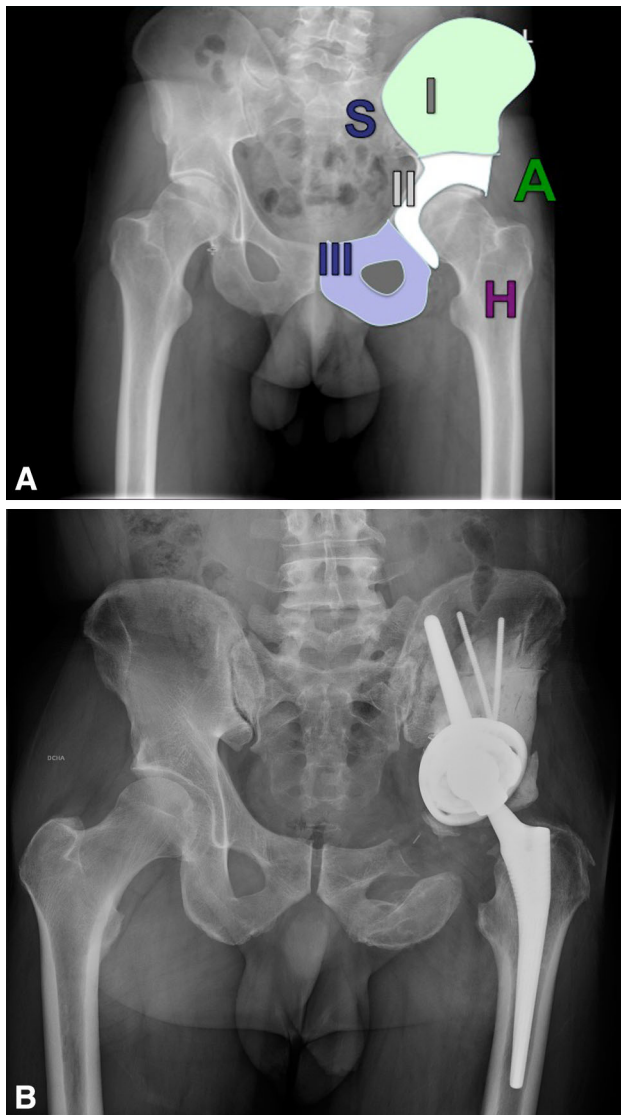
B (A) This picture shows a pelvic chondrosarcoma radiograph with the Enneking and Durham classification of the pelvic resection zones. H = hip; S = sacrum; A = abductor muscles. (B) This is a postoperative radiograph of the same patient showing the Ice-Cream Cone prosthesis that was implanted after an internal hemipelvectomy in a patient with a chondrosarcoma located in the periacetabular area.
